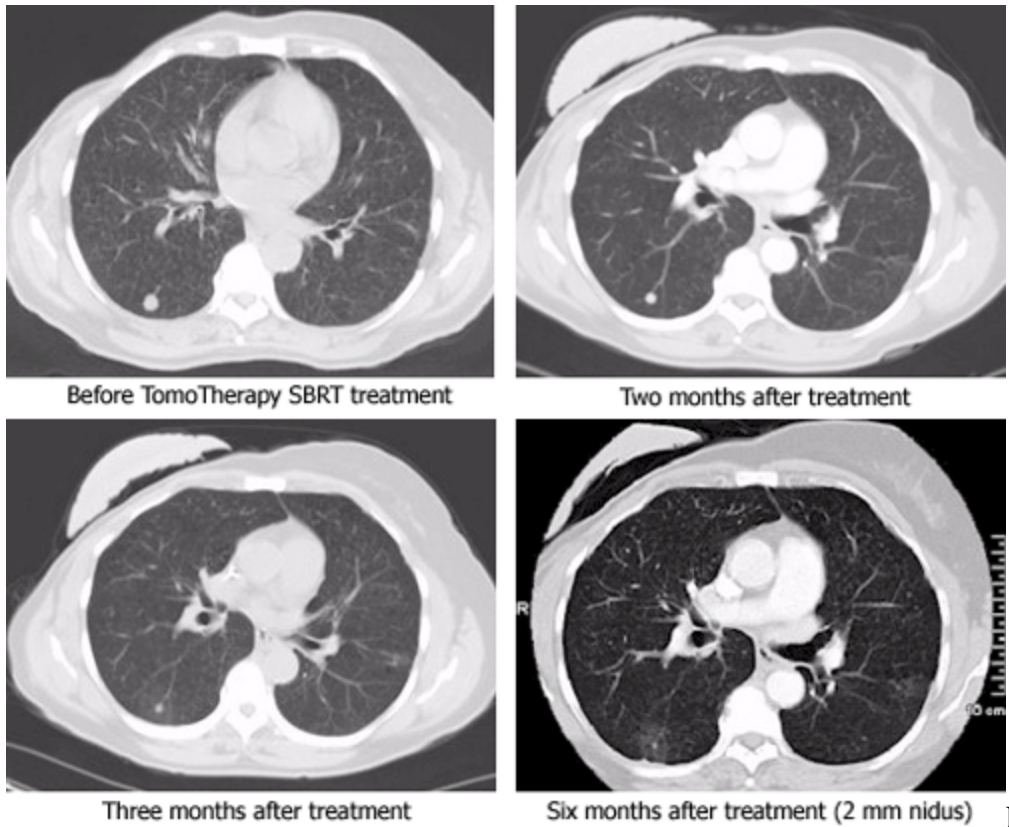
CT scans showing tumor response and treatment accuracy of *TomoTherapy* SBRT.
